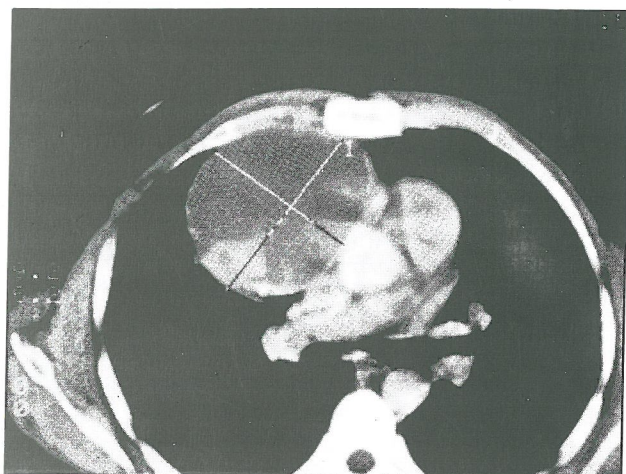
CT Scan confirms the location, the size of the lesion and the cystic appearance.
